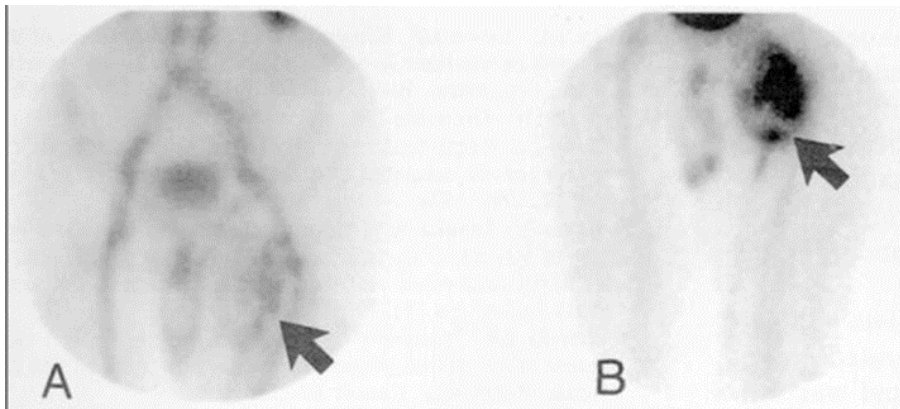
^{99m}Tc -DD-3B6/22 scintigraphs of the proximal thighs obtained (A) immediately and (B) 6 h PI, displaying increased tracer uptake in a fibrous histiocytoma (arrows). Reprinted from Angelides and coworkers with permission from the publisher.¹⁶⁵
